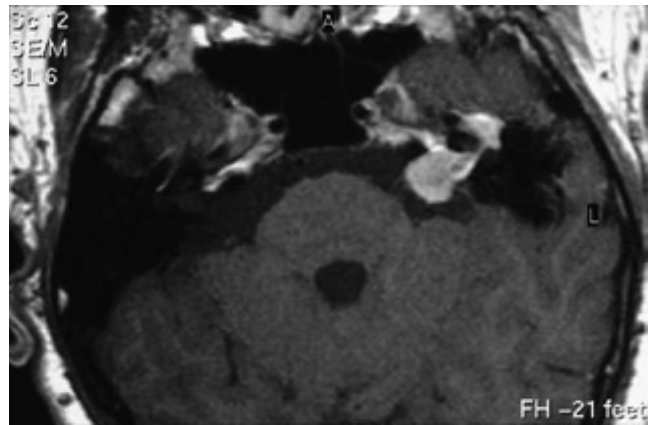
Axial T1 weighted MRI with contrast showing facial schwannoma filling the internal auditory meatus and extending along the greater superficial petrosal nerve into the middle fossa.
